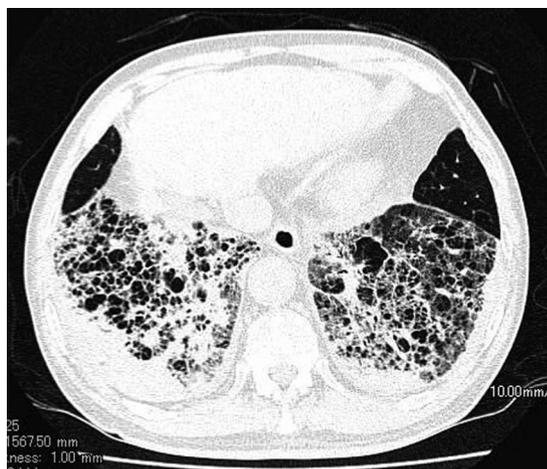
Thoracic computed tomography (CT) on initial admission showing emphysema, reticular shadow, ground-glass attenuation, and subpleural consolidation. The reticular shadow was mainly located in the lower fields of bilateral lungs. Bilateral pleural effusion was also seen.
